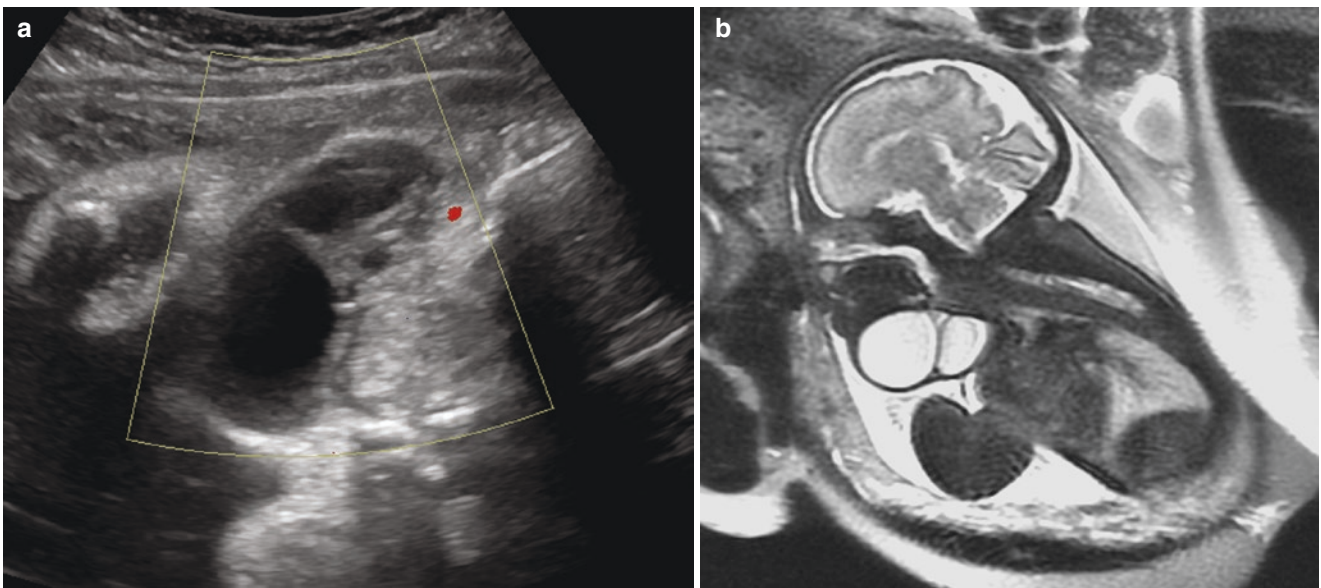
Cervical lymphangioma. (a) Axial US image of the fetal neck demonstrates several macrocysts with no significant vascularity. (b) Sagittal SSFSE T2w MR image of the fetal neck at 30 weeks' gestation
